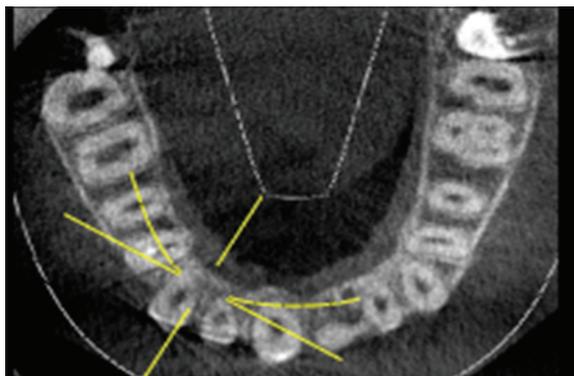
Cone beam computed tomography axial image showing impacted tooth
